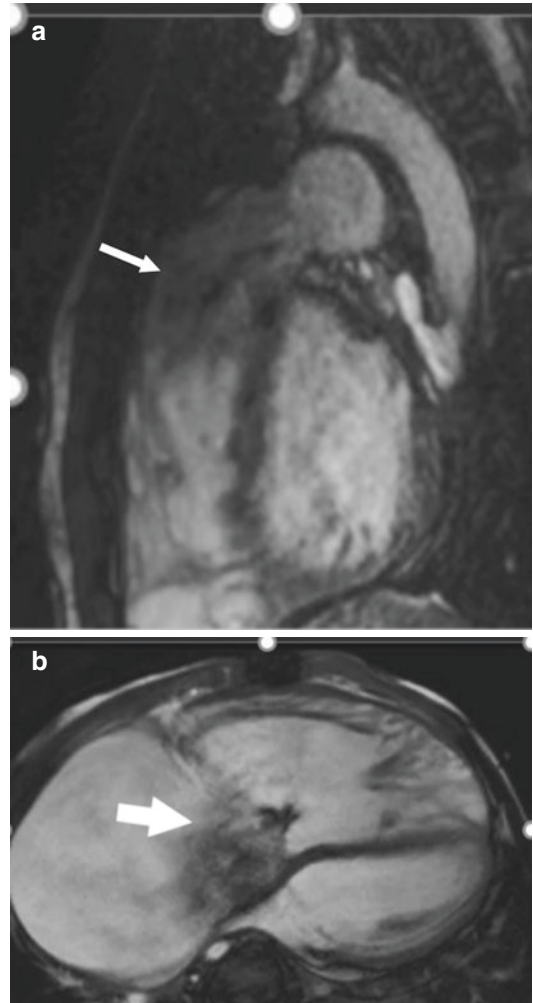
Valvular heart disease. (a) Sagittal MRI image showing severe pulmonic regurgitation (arrow). (b) 4-chamber SSFP image showing severe tricuspid regurgitation (arrow)
